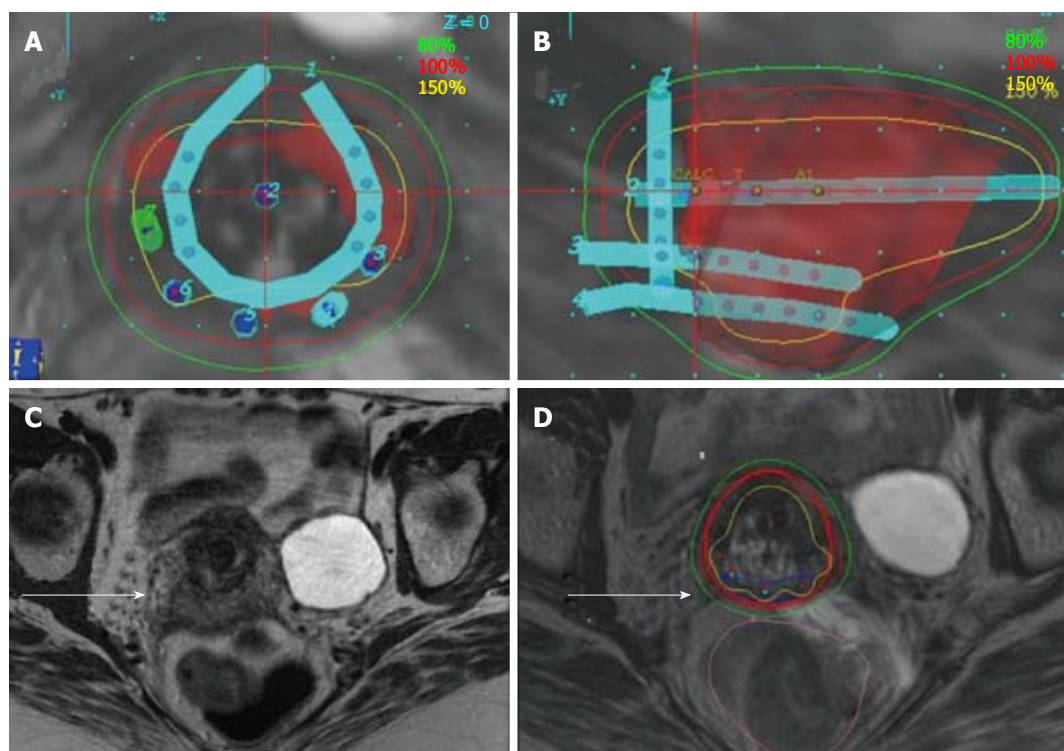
Use of the Vienna applicator to improve posterior disease coverage for locally-advanced cervical cancer. A and B: 3D reconstruction of Vienna applicator showing posterior needles; C and D axial magnetic resonance imaging (MRI) showing advanced disease with posterior extension, and improved coverage with combined interstitial and intracavitary MRI image-based planning.
